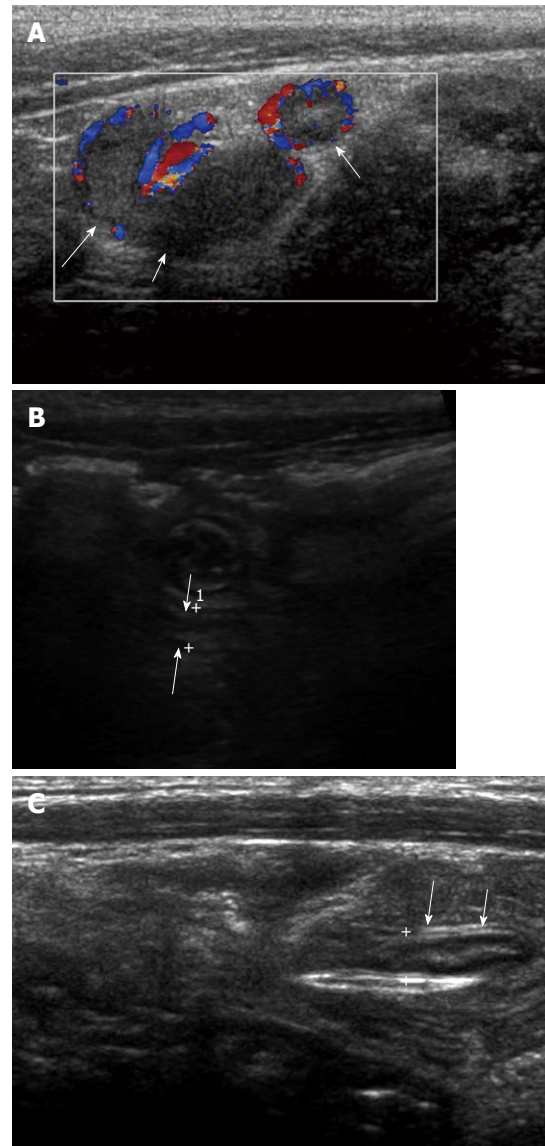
A 6-year-old male with acute appendicitis and fever. A: Distended appendix with dirty intraluminal fluid and hyperemia of appendiceal wall on color Doppler study (arrows). Periappendiceal mesenteric fat infiltration was identified; B: Because of lobar pneumonia, surgery was delayed and antibiotic therapy given. On follow-up ultrasonography 3 d later, the maximal outer diameter of appendix (arrows) was decreased to 4 mm with disappearance of intraluminal content; C: On follow-up after 6 d, the wall layers of the appendix (arrows) had recovered significantly. Periappendiceal mesenteric fat change had almost resolved.
